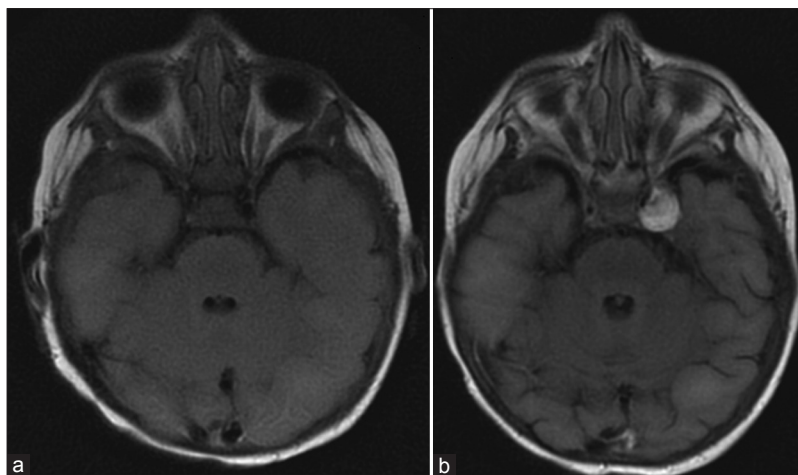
MRI at initial diagnosis (a) Axial T2-weighted fluid-attenuated inversion recovery (FLAIR) MRI showing features of tuberous sclerosis, including white matter radial migration lines and cortical tubers. MRI at presentation of cranial nerve deficits (b) Axial T2-weighted FLAIR MRI showing an 18-mm left cavernous sinus internal carotid artery aneurysm
